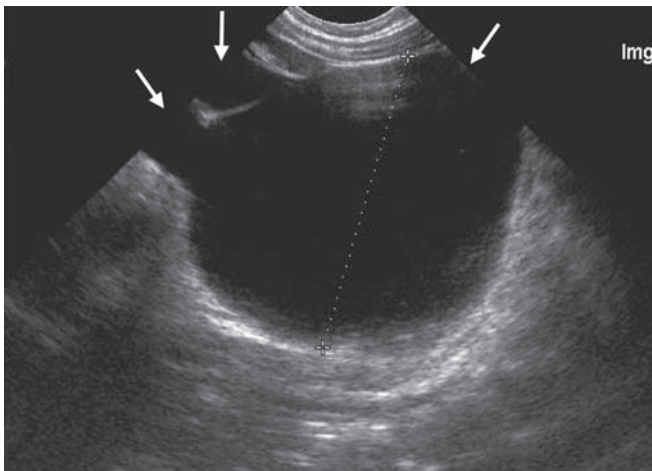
Ureteropelvic junction obstruction. Longitudinal ultrasound scan demonstrates markedly dilated renal pelvis and moderately dilated calyces (arrows)
